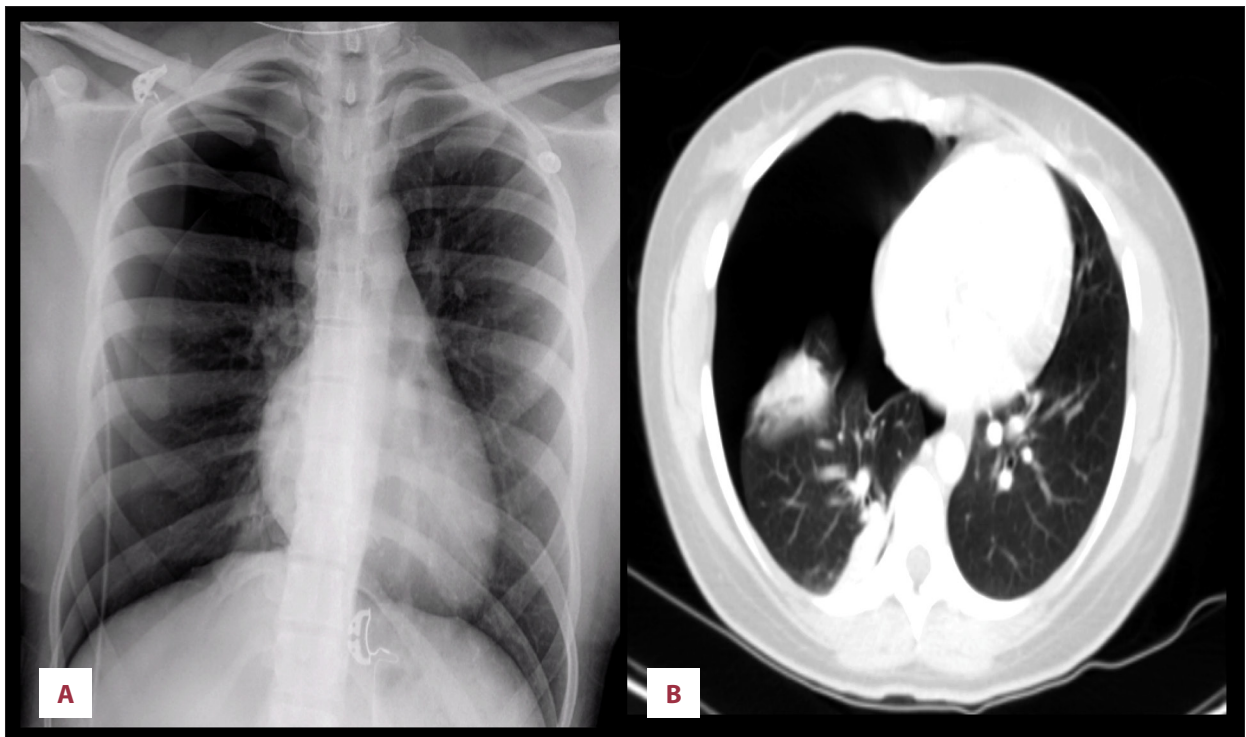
(A) Chest X-ray and (B) computerized tomography demonstrating 50% pneumothorax.
